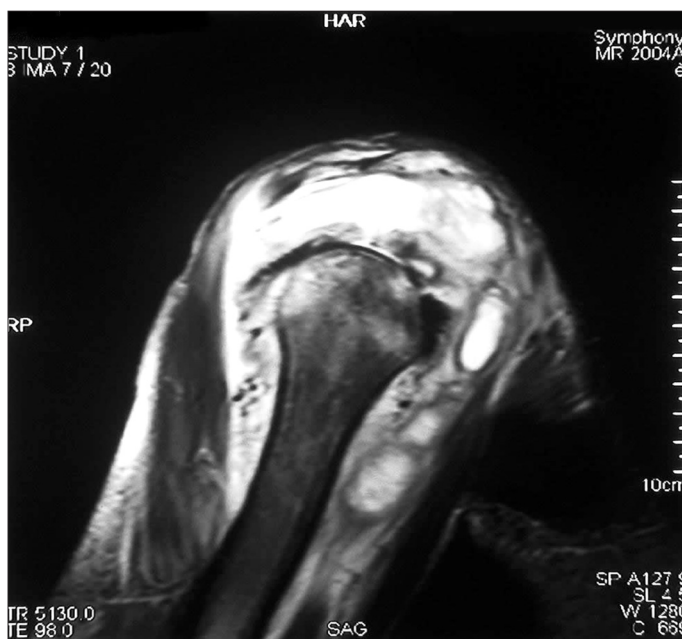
Oblique T2-weighted sagittal section of the right shoulder demonstrated multilocular fluid collections in the subacromial and subdeltoid regions including the subscapularis and deltoid muscles as well as prominent effusion and synovial thickening of the shoulder joint.
